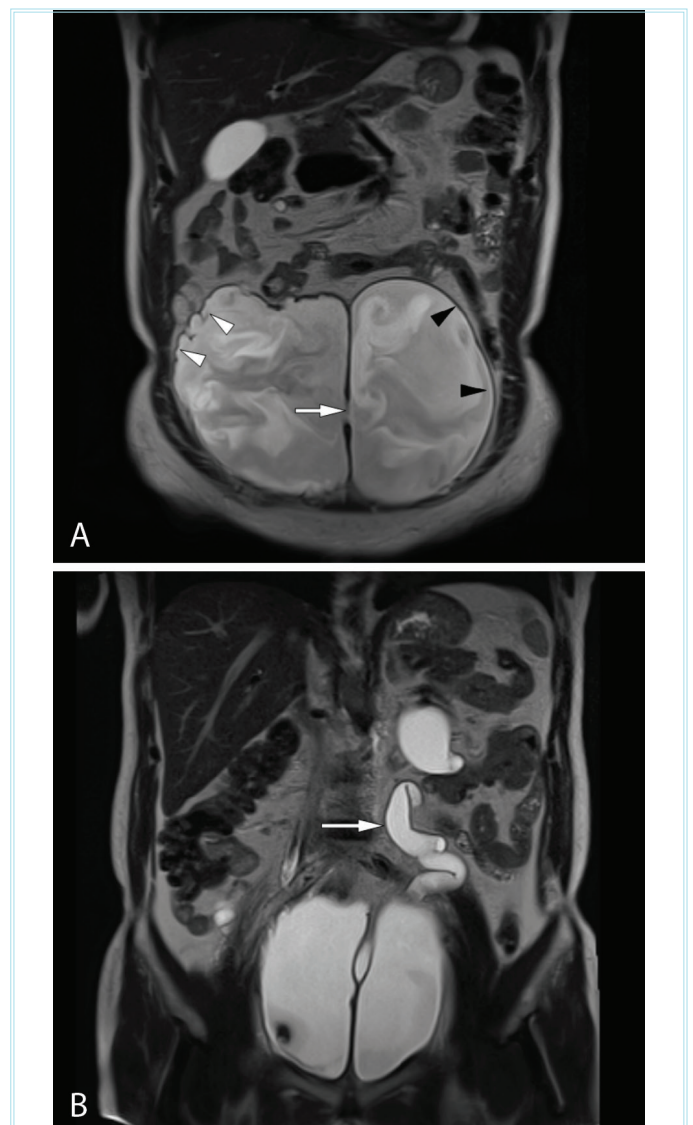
Magnetic resonance imaging (MRI) demonstrating narrow neck (arrow) between the diverticulum and the bladder lumen, trabeculated appearance on the bladder wall (white arrowheads), a thin wall structure of diverticulum (black arrowheads) (A). MRI demonstrating the left ureter between the diverticulum and the bladder, dilated and tortuous proximal to this level (arrow) (B)
